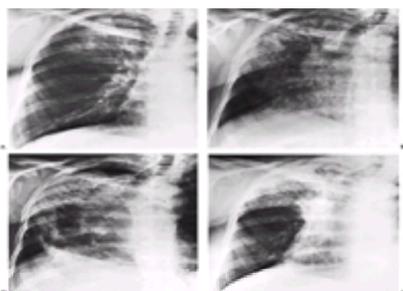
Roentgenograms of a 54-year-old woman who had a right radical mastectomy for breast cancer and subsequent radiation therapy. (A) 3-19-73. Three weeks after completion of radiation therapy (B) 4-10-73. More extensive changes in parenchyma with retraction indicated by tracheal deviation, diaphragmatic elevation, and air bronchograms. Patient was symptomatic at this stage. (C) 4-30-73. More extensive changes of radiation pneumonitis with pneumothorax at right apex and a fluid level. Pneumothorax resolved spontaneously. (D) 12-11-74. Late roentgenographic appearance showing resolution of changes in mid and lower zones, radiation
